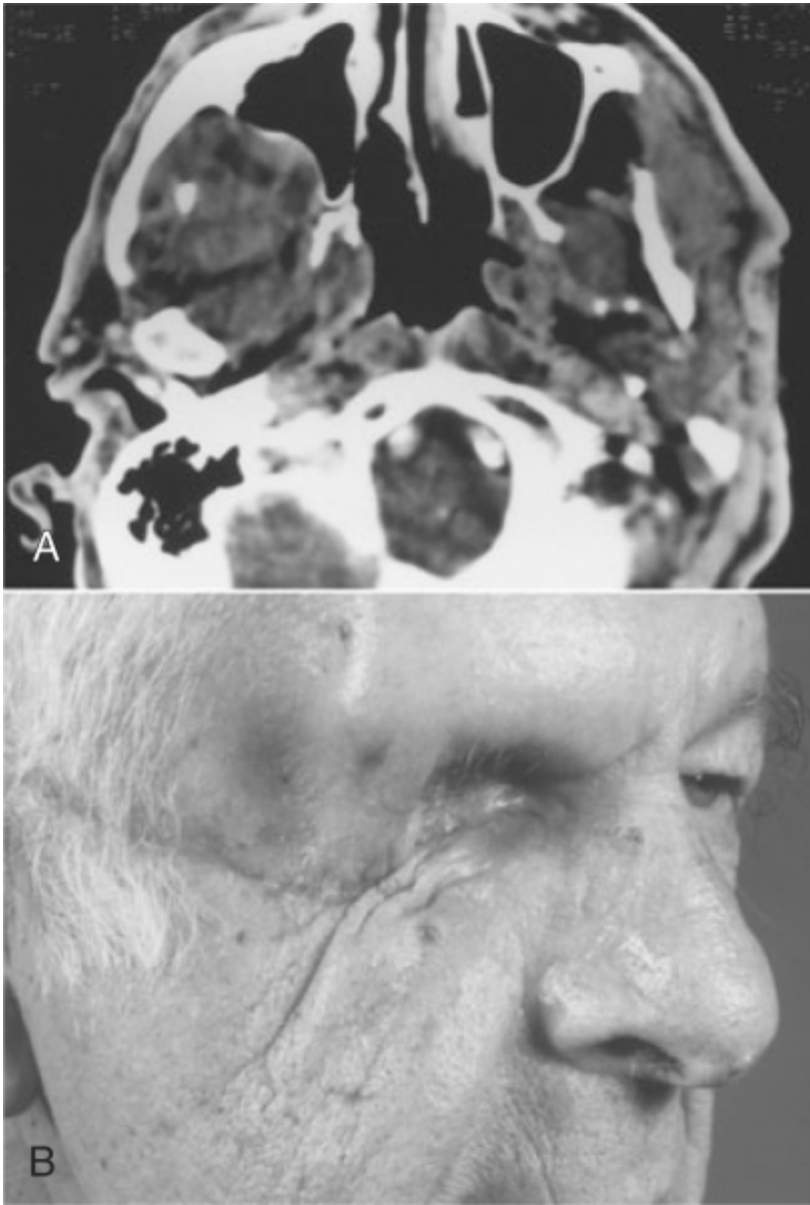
A, Computed tomography scan demonstrating hemangiopericytoma of the right temporal area with involvement of the temporalis muscle, orbitozygomatic bone, and orbit. B, Resection of the temporalis muscle, lateral orbital wall, zygomatic bone, and orbit was necessary to achieve clear tumor resection margins but resulted in a significant cosmetic deformity.
